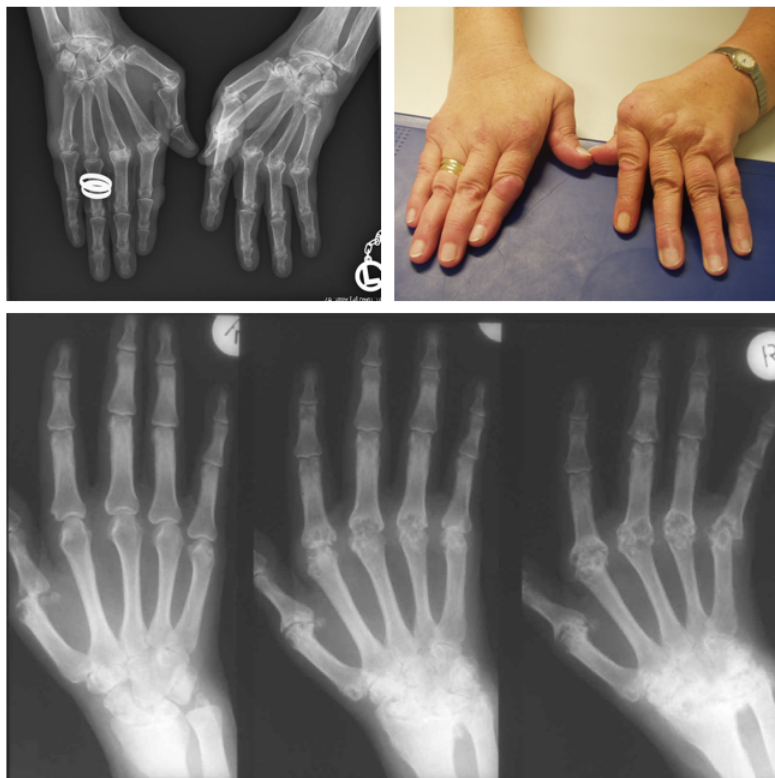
Clinical presentation of rheumatoid arthritis (RA) Top: Hands of an advanced stage RA patient (x-ray and photograph) with prominent ulnar deviation in all MCPs. Bottom: X-ray images over the course of RA. Left: Early inflammation in the carpus, luxation of the metacarpophalangeal (MCP) joints; Middle: Luxation, inflammation and destructive changes at all MCPs and formation of an os carpale; Right: advanced inflammatory destructive manifestations.
